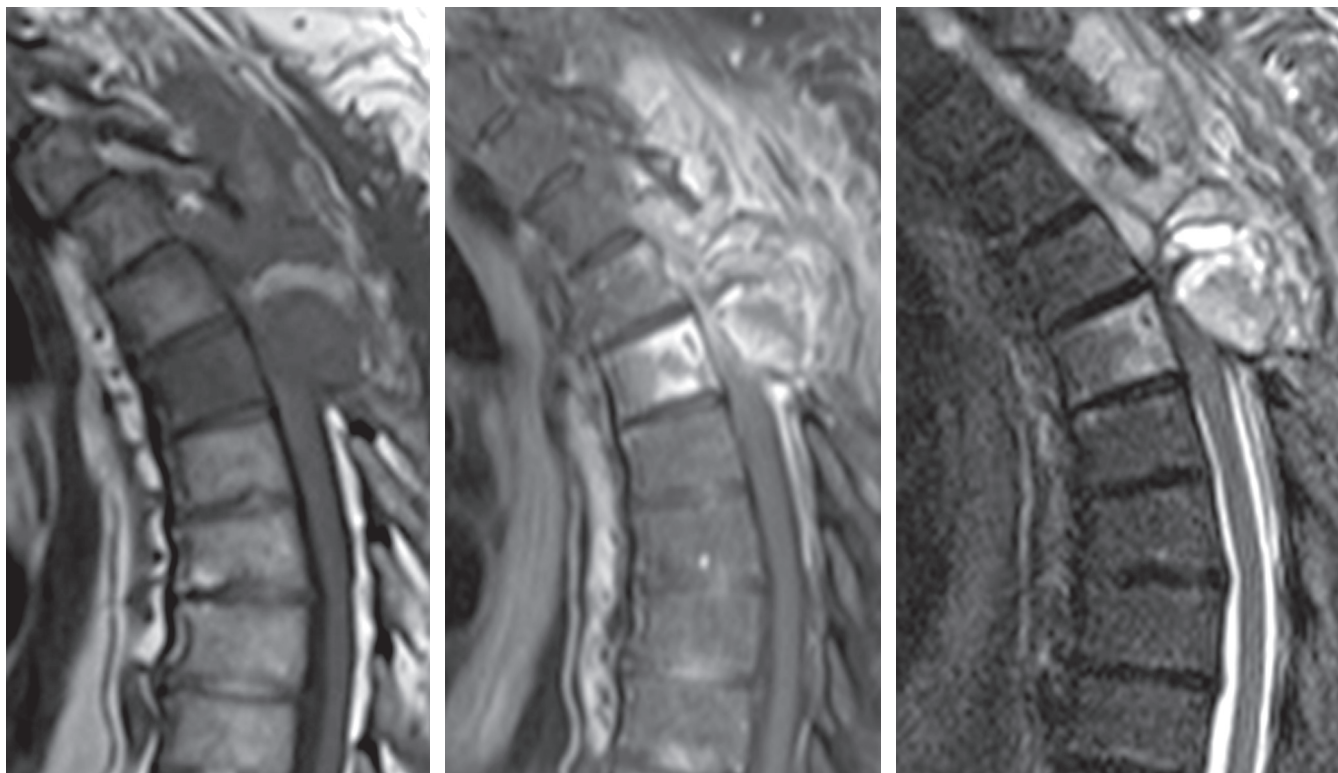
Sagittal MRI in the same patient 3 months after diagnosis shows recurrence of the posterior epidural tumor at the site of the first surgery, now with anterior and posterior bone involvement and severe cord compression with rostral edema. Note heterogenous enhancement. (Left) T1-weighted; (Middle) fat-suppressed, gadolinium-enhanced; and (Right) T2-weighted studies.
